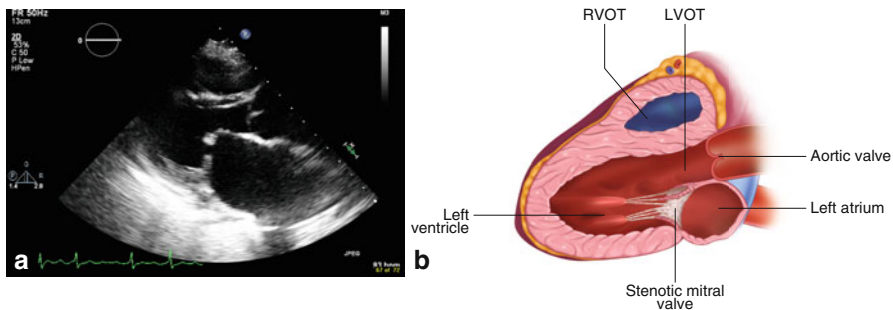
(a) Echocardiogram (parasternal long axis view) showing the mitral valve with hallmarks of mitral stenosis including thickening of the valve and tethering of the anterior mitral valve leaflet. (b) Artist rendering of a parasternal long axis view of the myocardium on echocardiogram. Note the thickened calcified valves characteristic of mitral valve stenosis. Symptoms typically occur once the MV area measures between 1.2 and 1.6 cm²
